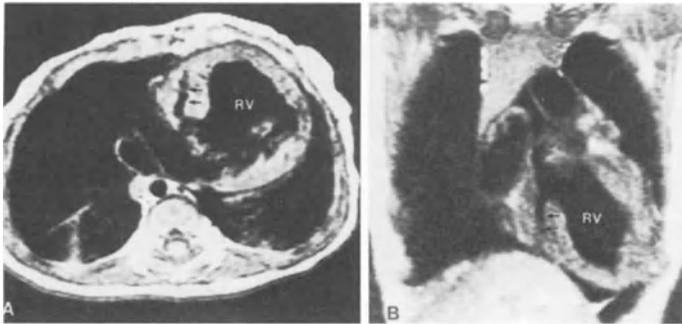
Axial (A) and coronal (B) MR images of RV type single ventricle. A small rudimentary left ventricle (arrows) occupies the right side of the large right ventricle (RV)
